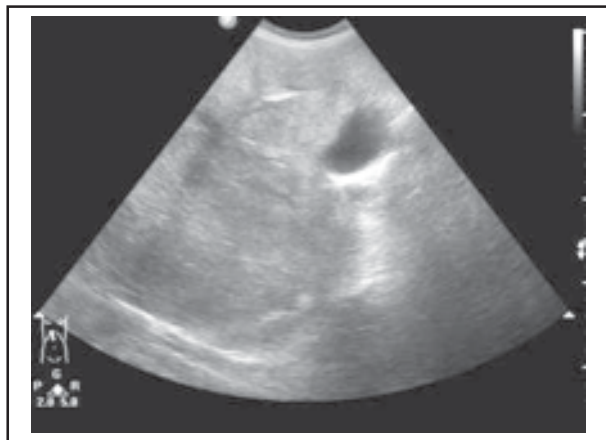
Abdominal colour Doppler ultrasonography detected huge hyperechoic lesions with compression to the bile ducts, portal vein and inferior vena cava (IVC), and which reveal the diagnosis of multiple giant hemangiomas.
